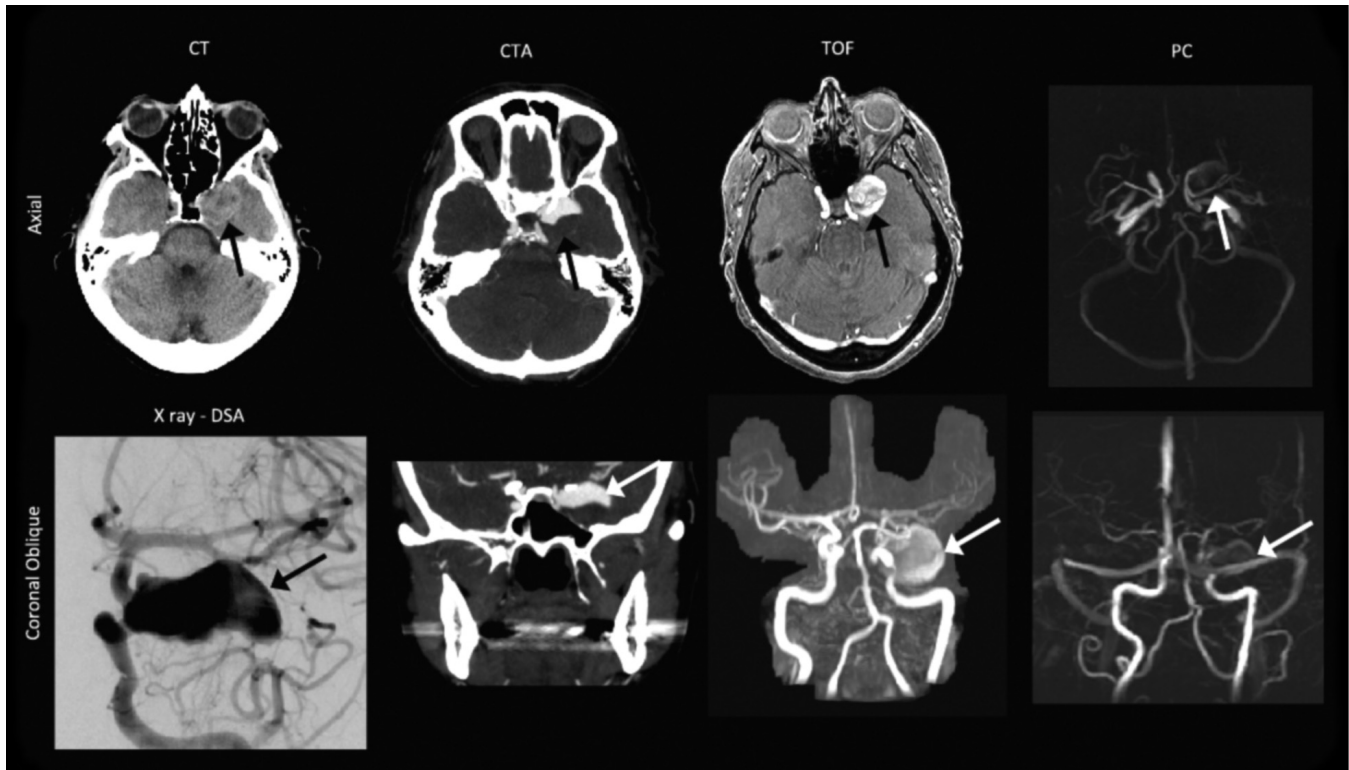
Pre-operative computed tomography (CT), CT angiography (CTA), digital subtraction angiography (DSA), noncontrast-enhanced time-of-flight (TOF) imaging, and phase-contrast (PC) imaging. The aneurysm (black and white arrows) was clearly depicted on the combination of axial and coronal orientations. The coronal TOF and the PC images are maximum-intensity projections.
